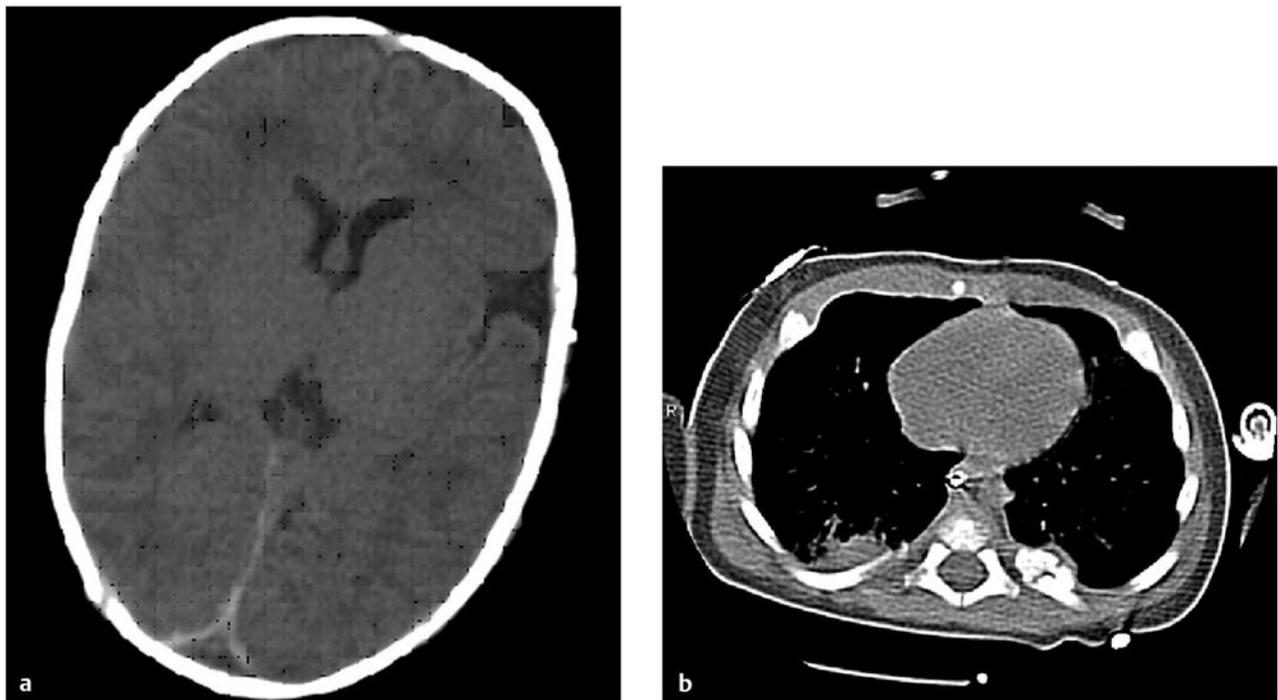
Unenhanced computed tomographic (CT) scan of a 6-week-old baby who was found at home unresponsive with irregular breathing. There was no history of trauma. (a) Axial view through the brain showing interhemispheric blood. (b) CT scan of the chest showing a healing left posterior rib fracture.
